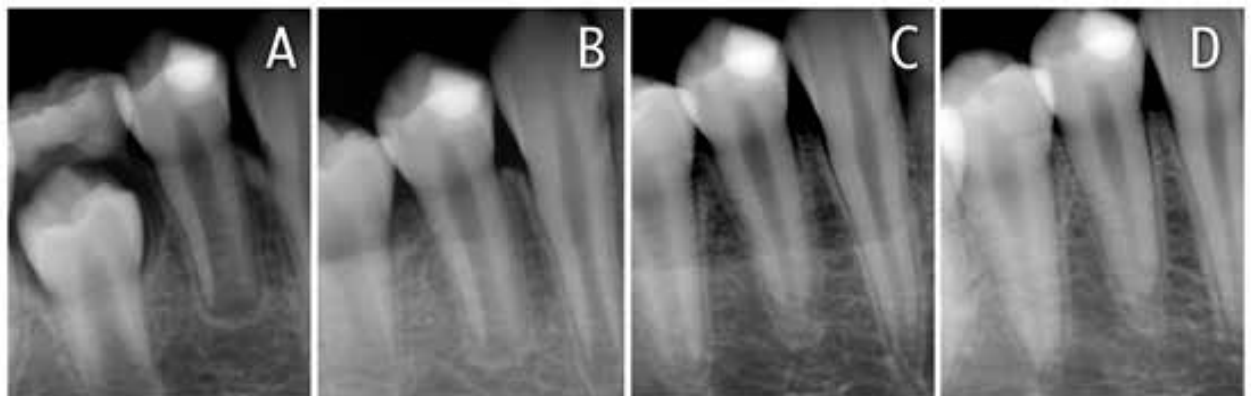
(a) Periapical radiograph taken at the one-year recall visit. Note the continued root development with evidence of a thin dentine bridge at the exposure site; (b) Periapical radiograph taken at the two-year recall visit. Note the continued root development; (c) Periapical radiograph taken at the three-year recall visit clearly showing complete root formation and apex closure; (d) Periapical radiograph taken at the four-year recall visit showing complete root formation with a normal periodontal ligament.
